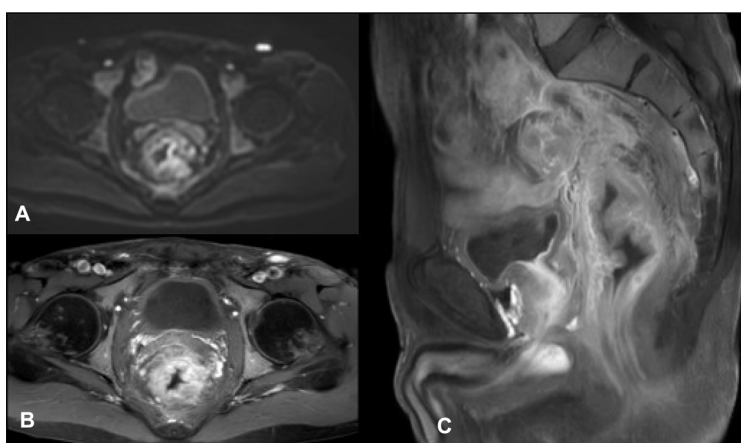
DWI sequence (A), axial (B) and sagittal (C) T1 FAT SAT postcontrast sequences demonstrate restricted diffusion and tumor enhancement.
